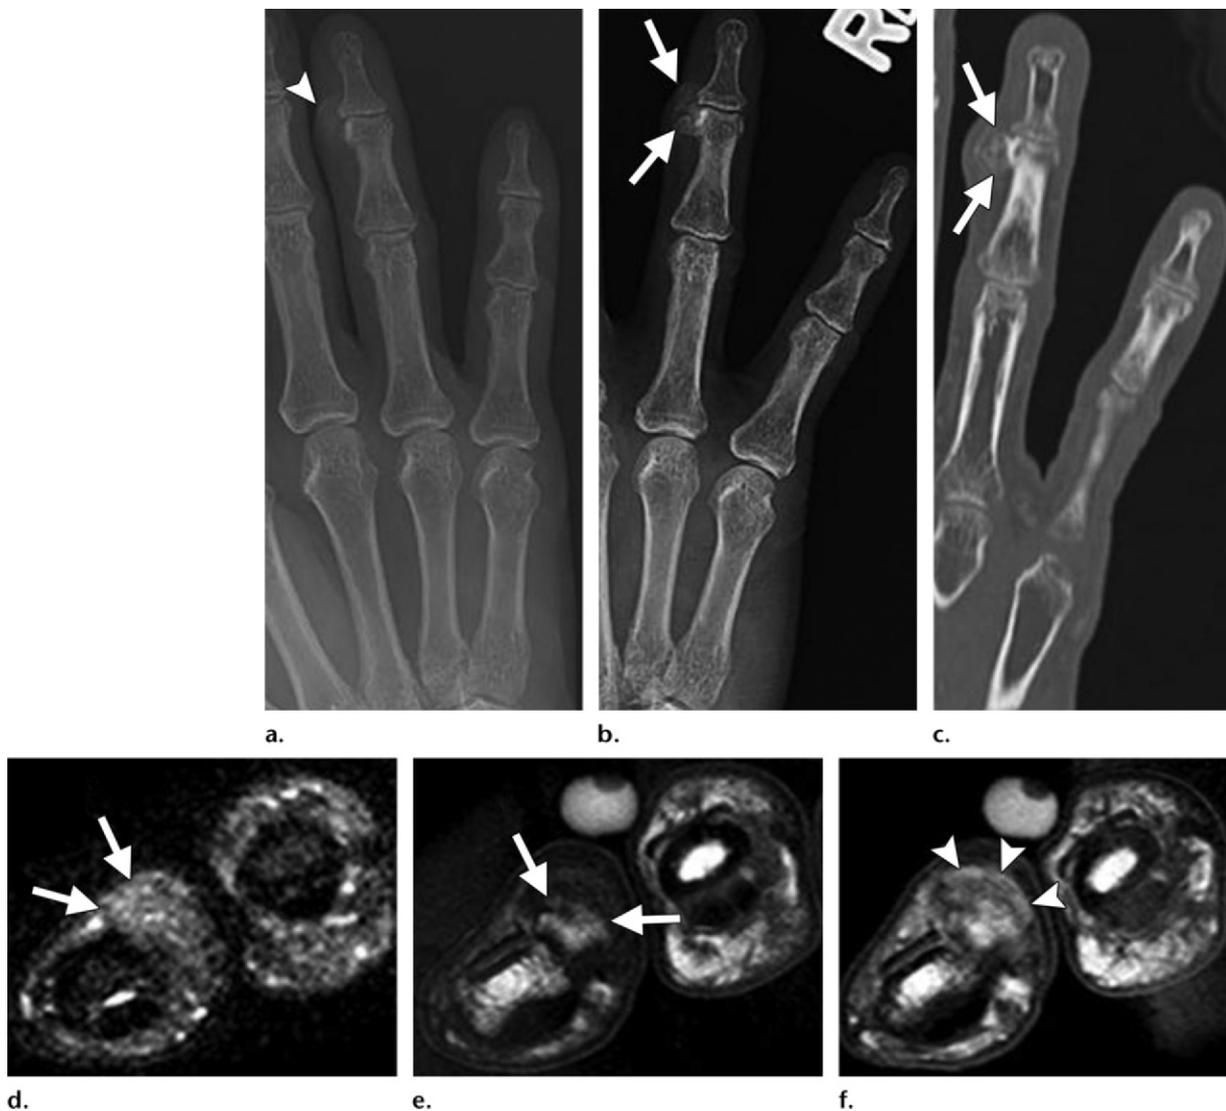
Bizarre parosteal osteochondromatous proliferation (Nora lesion). (a, b) Frontal radiographs obtained in 2008 (a) and 2011 (b) demonstrate interval growth of an osseous excrescence (arrowhead in a, arrows in b) at the radial aspect of the distal interphalangeal joint of the ring finger, with central internal matrix. (c) Coronal nonenhanced CT image shows a well-corticated nodular osseous lesion at the middle phalanx of the ring finger (arrows). Note the lack of continuity with the underlying marrow. (d, e) Short-axis STIR (d) and T1-weighted (e) MR images show an exophytic pedunculated osseous lesion (arrows) arising from the radial aspect of the middle phalanx of the fourth digit, with a heterogeneous hyperintense cap on the STIR image. (f) Gadolinium-enhanced fat-suppressed T1-weighted MR image shows the cap with intense enhancement (arrowheads).
